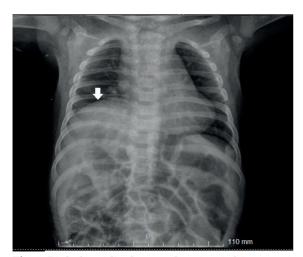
Right hemidiaphragm elevation (white arrow) on chest X-ray at 5 months old.
